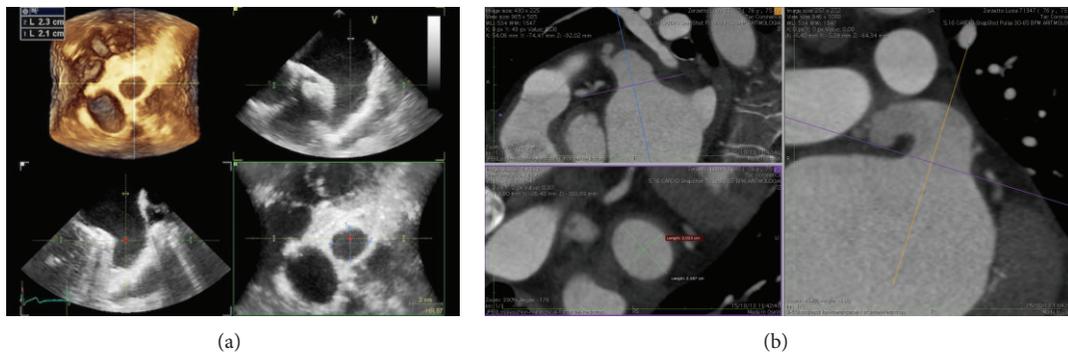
Left atrial appendage measures with transesophageal echocardiography (a) and CT scan (b).
